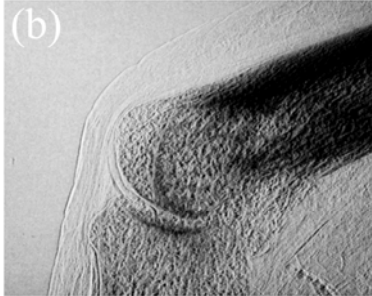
X-ray images of normal PIP joint without an intensifying screen.
